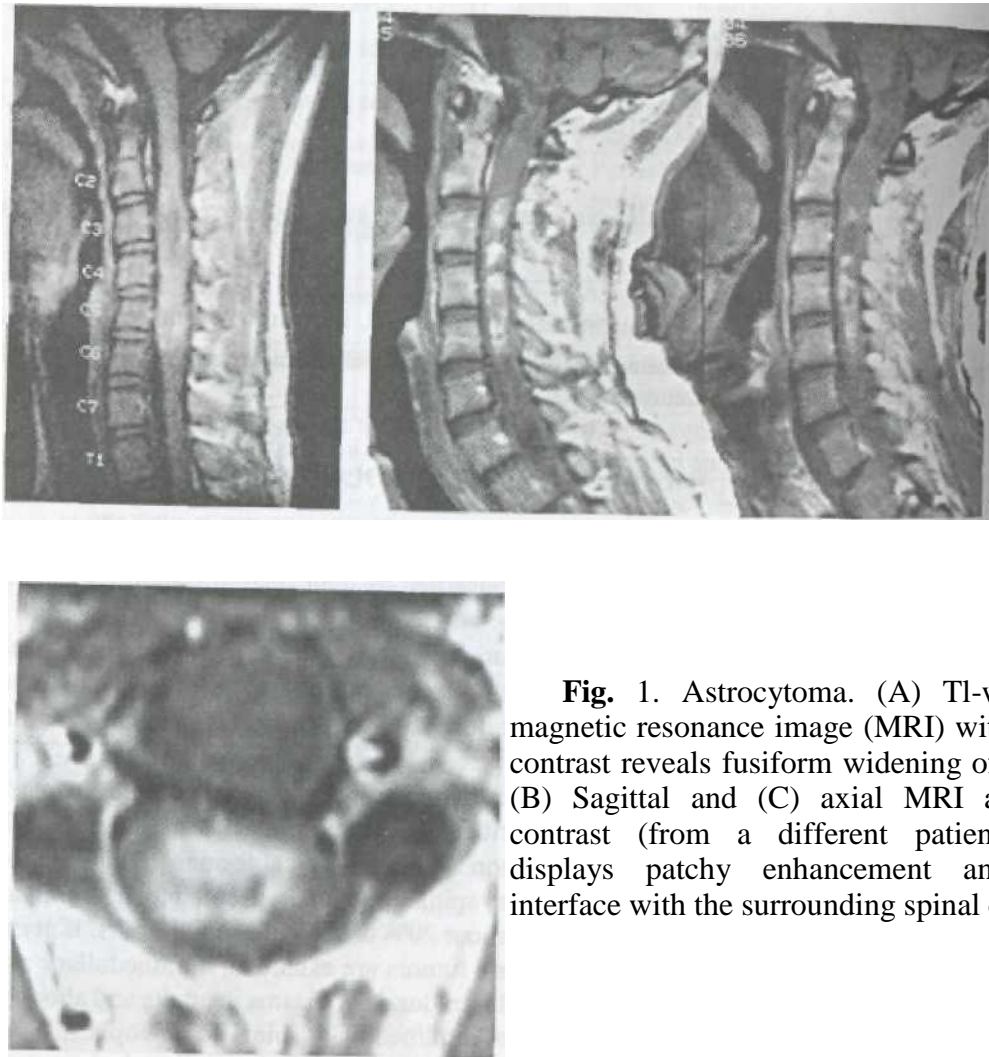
Astrocytoma. (A) T1-weighted sagittal magnetic resonance image (MRI) without intravenous contrast reveals fusiform widening of the spinal cord- (B) Sagittal and (C) axial MRI after intravenous contrast (from a different patients). The tumor displays patchy enhancement and an irregular interface with the surrounding spinal cord.
